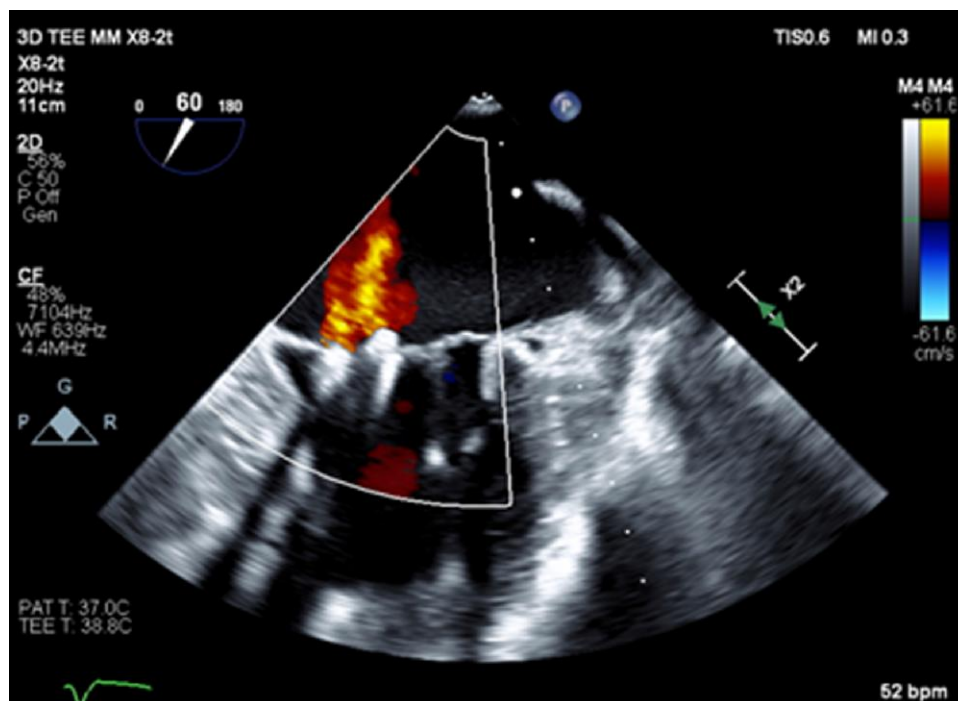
Echocardiogram—post second clip insertion.
